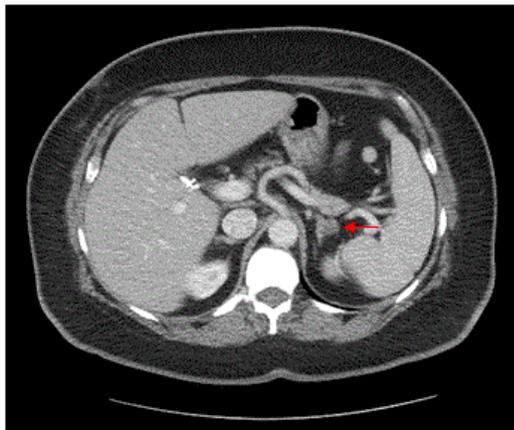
CT demonstrating left adrenal mass (arrow).
